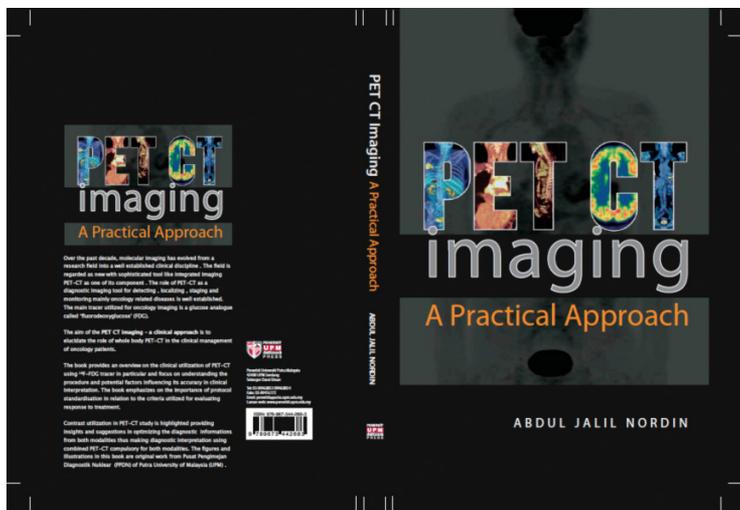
"PET-CT Imaging - A Practical Approach" an out come from the International Network- Collaboration between PPDN UPM and Medical University of Innsbruck in ASIA UNINET
